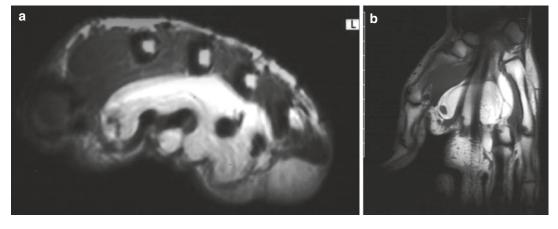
(a, b) Lipoma of the tendon sheath of the hand in a 31-year-old man. (a) Axial SE T1-weighted MR image. (b) Coronal SE T1-weighted MR image. MR
